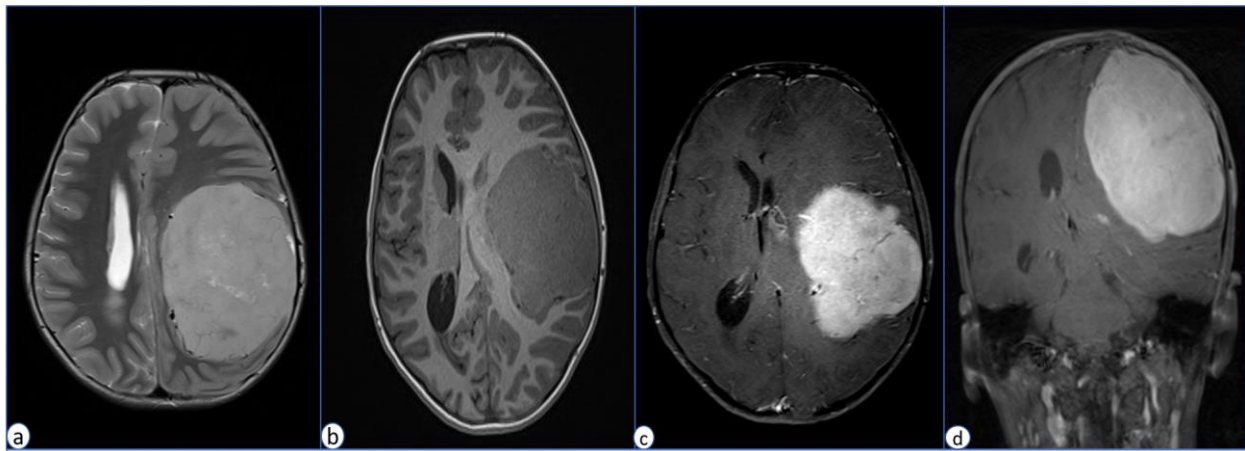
(a, b, c, d) MRI scan, (sagittal, coronal), shows a large well defined left fronto-parietal extra-axial mass lesion irrelatively homogeneous high T2/FLAIR and low T1 signal intensity measuring about 8.7cm x 7.1cm x7.7cm in it's maximum AP, TR, CC dimensions respectively. Post contrast images the lesion showed avid mostly homogeneous contrast enhancement with some none enhancing central component likely representing necrosis. The lesion is causing mass effect on the brain parenchyma causing 12mm midline shift.
